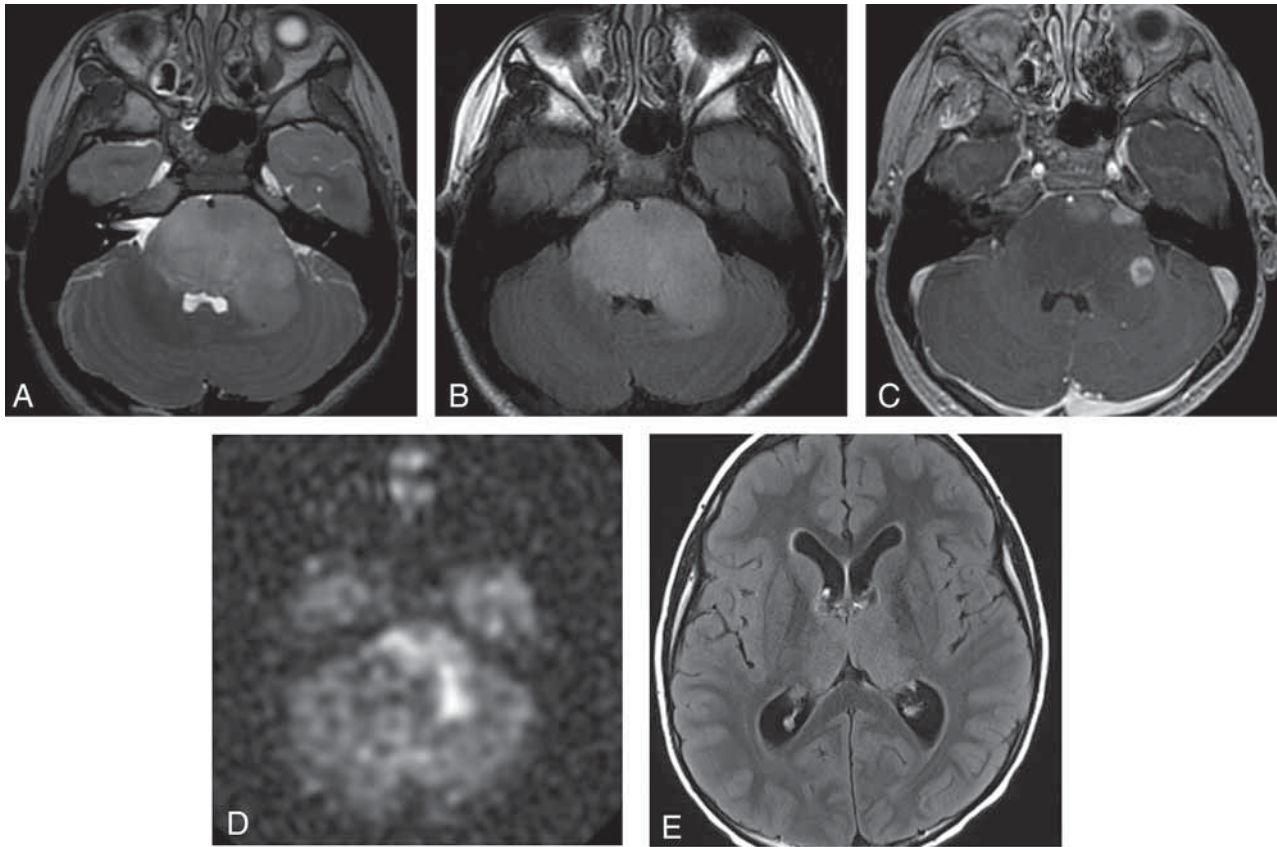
Pediatric-type diffuse high-grade gliomas. Diffuse midline glioma, H3K27-altered in an 8-year-old girl with cranial neuropathies. Axial T2 (A) and FLAIR (B) MR images show an expansile, hyperintense pontine mass. Axial postcontrast T1 MR image (C) shows heterogeneous enhancement within the mass. Arterial spin-labeling (ASL) perfusion (D) shows increased perfusion. E, Axial FLAIR MR image shows a bithalamic hyperintense mass. Postcontrast T1WI showed no significant enhancement, and ASL perfusion showed increased perfusion within the bilateral thalami (not shown). These WHO grade 4 tumors have a poor prognosis.
